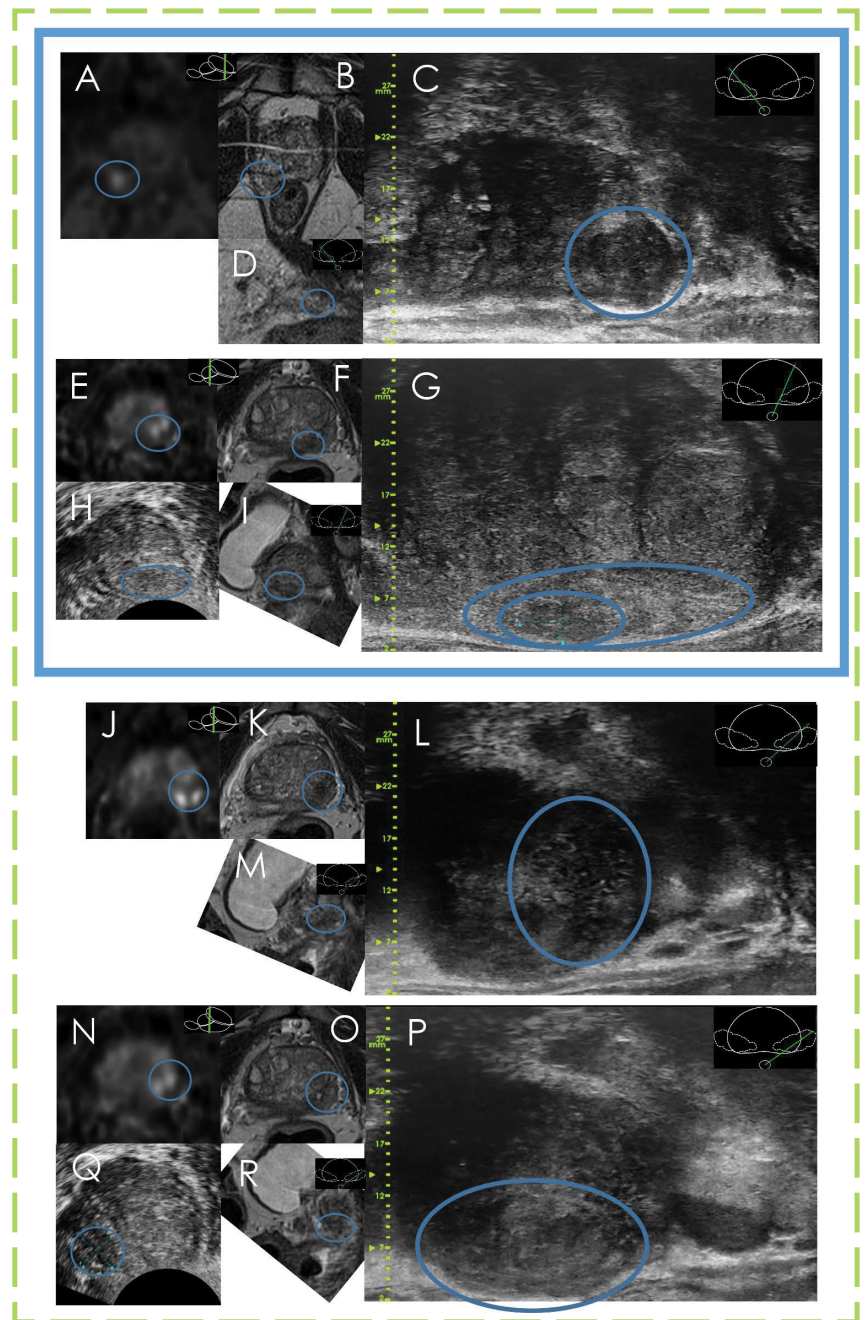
Lesions prospectively identified on both mpMRI and Micro-Ultrasound. The MRI is shown in panels A (DWI), and B (axial T2-weighted) with a blue circle highlighting the lesion. Panel D shows the same data resliced to match the para-sagittal view of the micro-ultrasound, along with the same circle highlighting the lesion. Panel C shows the micro-ultrasound image. This lesion was labeled as a PI-RADS 4 on mpMRI and a PRI-MUS 5 (mixed echo lesion) on micro-ultrasound. Pathology determined the lesion to be Gleason 9 with 20% core length.
